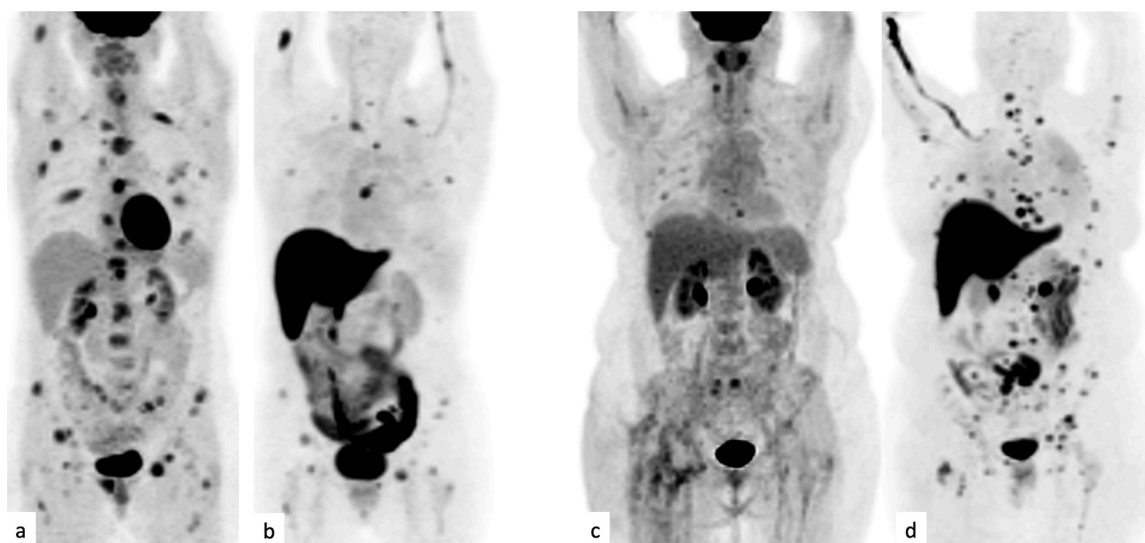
53-year-old woman affected by ER + BC bone metastases. ¹⁸F]FDG PET/CT (a) detected more bone metastases than [18F]FES PET/CT (b); the FES/FDG WB-B-MB ratio calculated was 0.79. The patient suffered disease progression and died of disease 20 months later. 60-year-old woman affected by ER + BC bone metastases. [18F]FDG PET/CT (c) detected fewer bone metastases than [18F]FES PET/CT (d); the FES/FDG WB-B-MB ratio calculated was 3.7. The patient did not suffer disease progression over time (i.e. 37 months) and is still alive.
